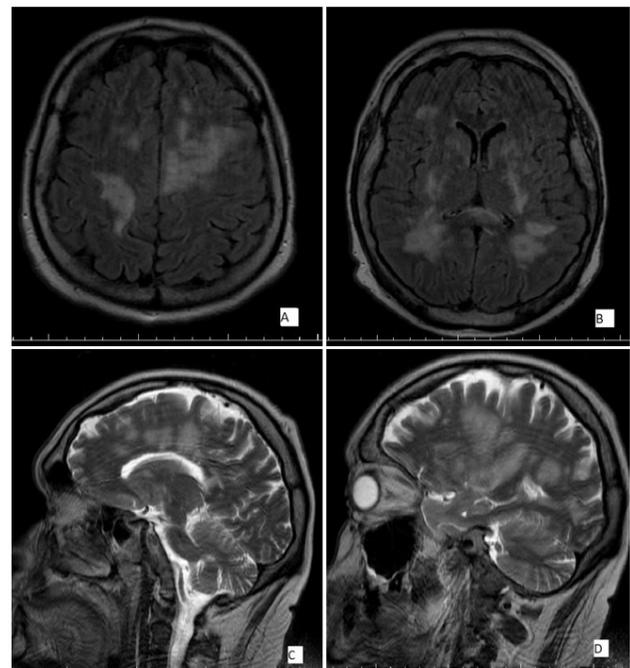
MRI of the CNS performed on the 21st of November 2016, after 2-week treatment with ABLC (T2-weighted images).
